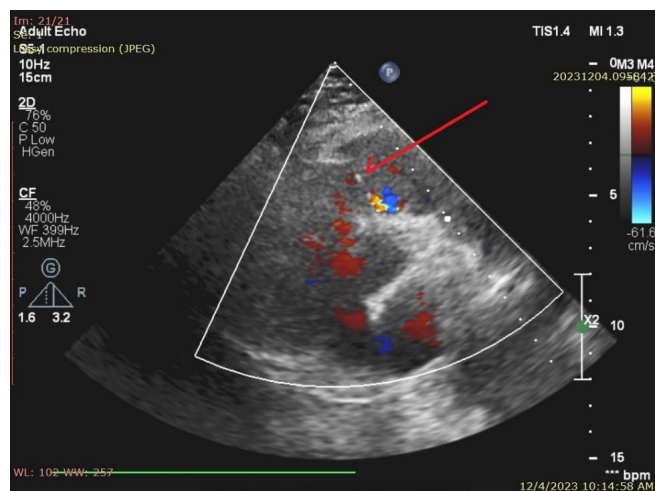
Postoperative echocardiography showing the monocusp of the pulmonary valve (indicated by the red arrow) completely closed during diastole. The right ventricular outflow tract (RVOT) is shown without any signs of regurgitation, demonstrating the successful outcome of the monocusp reconstruction procedure.
